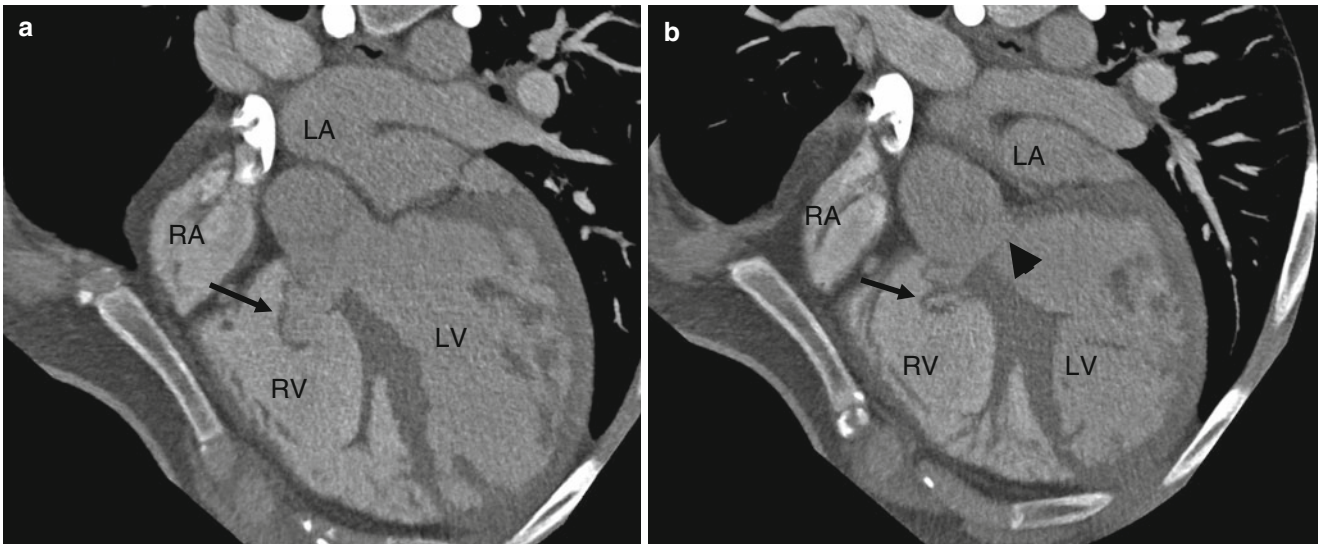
Example of a closing type 2 VSD associated with wind-sock deformity which did not result in complete closure. This abnormality likely resulted in the delayed onset of symptoms in this 28-year-old male. Panels (a) and (b) are oblique sagittal computed tomography scans showing prolapse of the tricuspid valve (black arrow)
